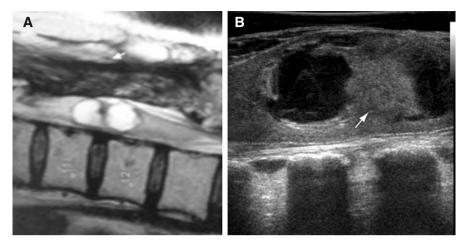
MRI (A) and US (B) of a medulla tumor with cysts
